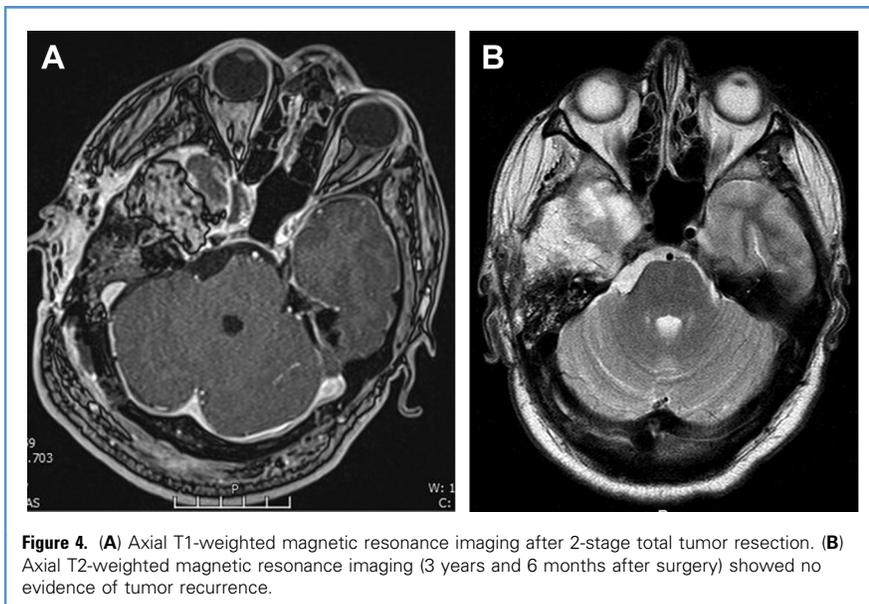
(A) Axial T1-weighted magnetic resonance imaging after 2-stage total tumor resection. (B) Axial T2-weighted magnetic resonance imaging (3 years and 6 months after surgery) showed no evidence of tumor recurrence.
